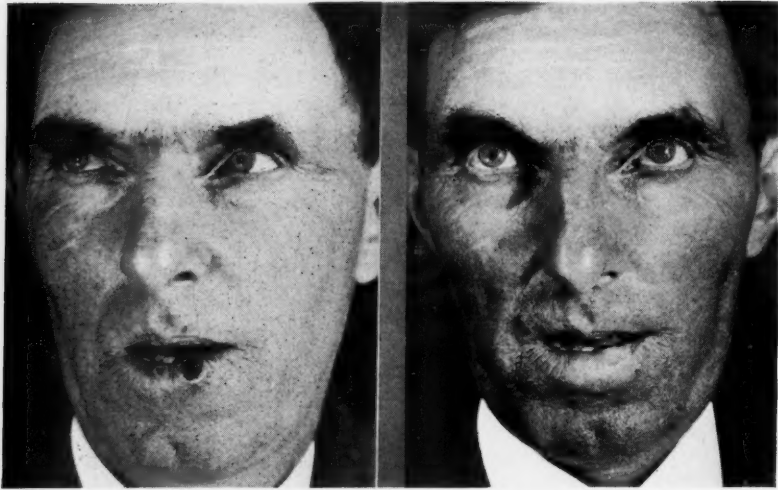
Early cancer of the lip. Most patients with lip cancer seek medical advice when the lesions are between 1 and 1.5 cm. in diameter. At this stage, the lesion commonly consists of a flat, slightly raised, painless and nontender ulcer of about ten to 12 months' duration. The edges tend to be raised and rolled. At this stage, metastasis has taken place in about 10 per cent of cases, as judged on the basis of the clinical presence of involved nodes on admission, or their later development after control of the primary lesion. (A) Before treatment. (B) Healed condition after roentgenotherapy, showing minimum of scarring and cosmetic deformity.
